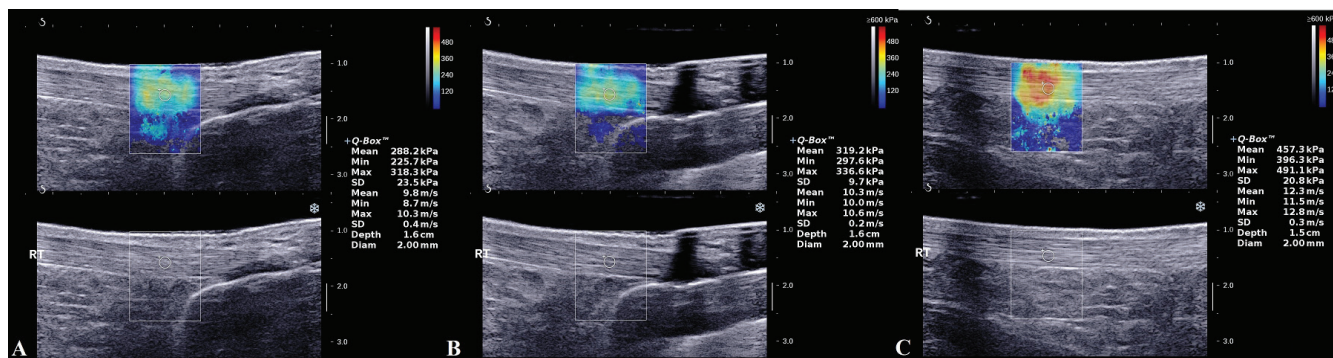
B-mode grayscale sonography and shear wave ultrasound elastography images of tendons (RT – right tendon). A. Irregular thickening around the Achilles tendon in the B-mode grayscale sonography (blue color image in the shear wave ultrasound elastography signifies low rigidity); B. Heterogeneity of echotexture of the tendon in the B-mode grayscale sonography (turquoise color image in the shear wave ultrasound elastography signifies intermediate rigidity); C. Calcification of the calcaneal attachment in the B-mode grayscale sonography (yellow to the red color image in the shear wave ultrasound elastography signifies high rigidity). A circle in the B-mode grayscale sonography represents the region of interest: 2-mm diameter
